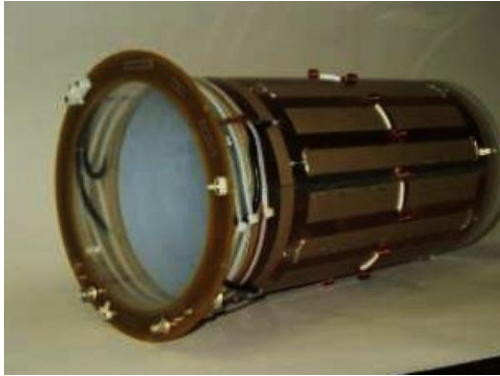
MRI RF coils (adapted from http://198.173.87.9/mri/mri_litzcagepg.htm)
